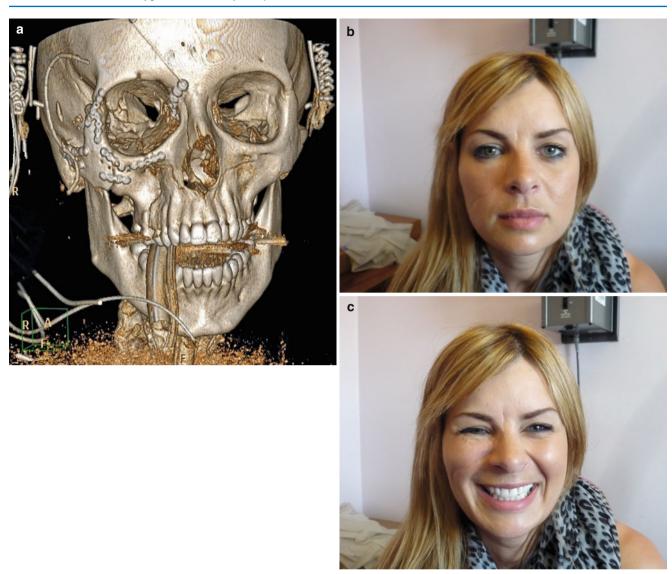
Postoperative CT and clinical appearances (a-c). Repair was undertaken through the original wound combined with a coronal flap
